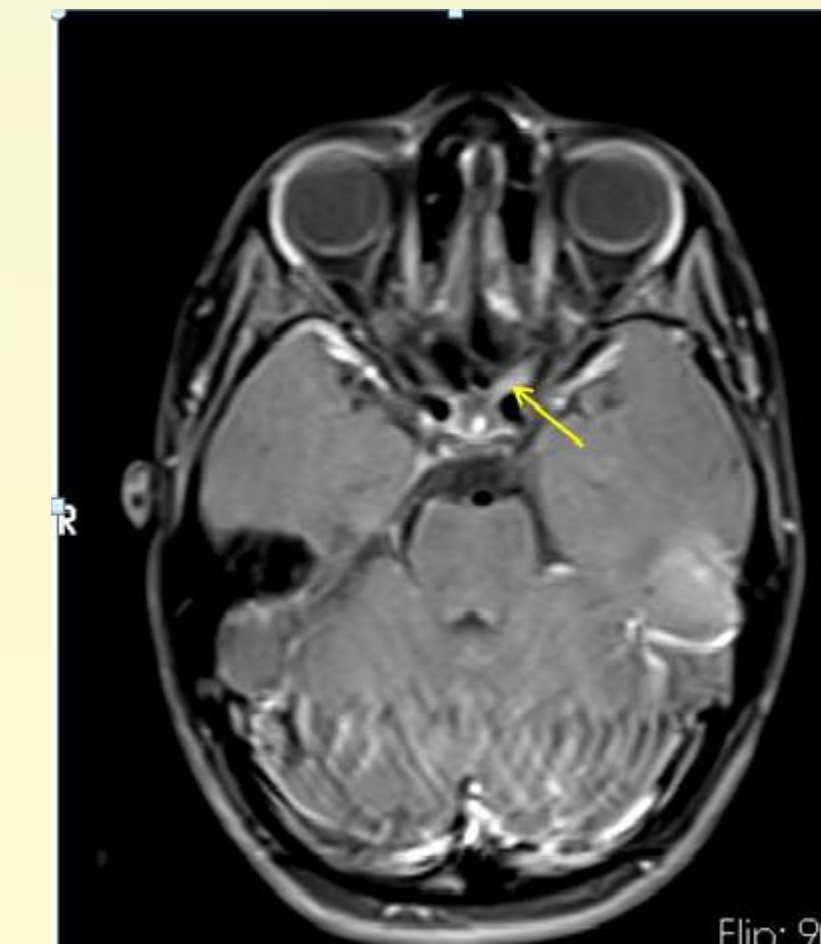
MRI showed suspected enhancement of the left optic nerve intracranial segment
